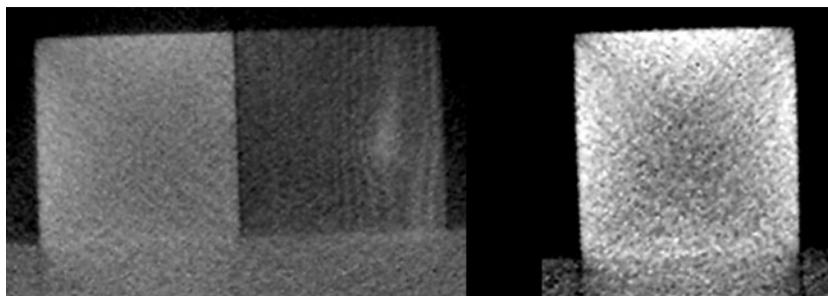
CBCT scan images of blocks constructed of various materials. Bright areas (higher HU) indicate areas of higher apparent density
